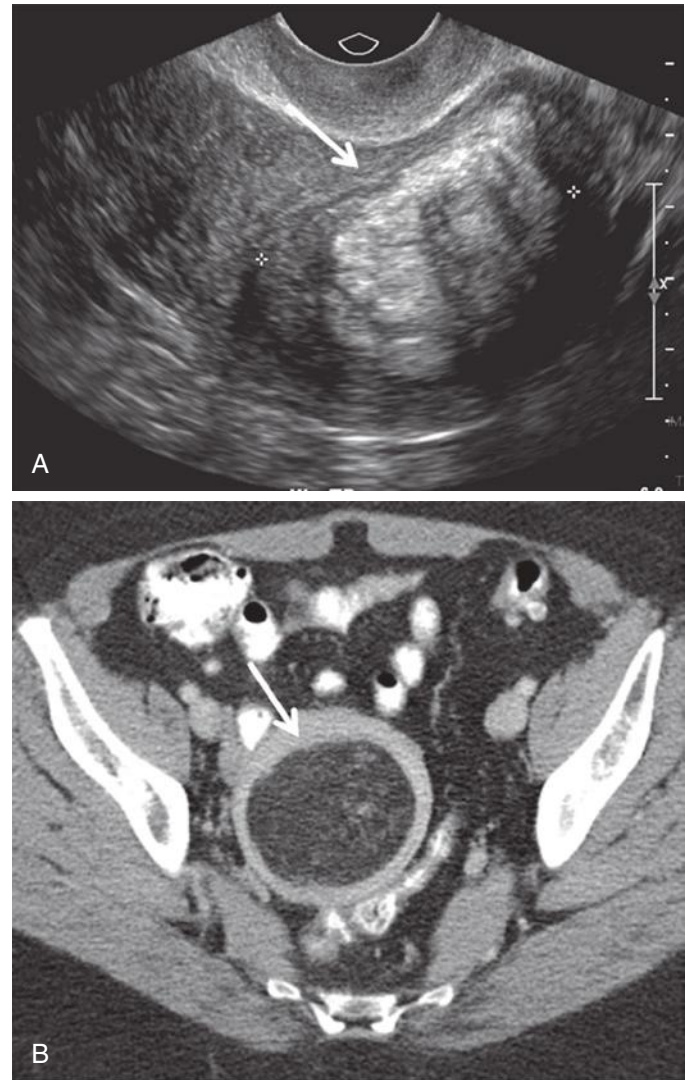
Lipoleiomyoma. A, Hyperechoic heterogeneous mass (arrow and calipers) in the uterus with a slightly lobular contour. B, Computed tomography confirms the presence of low attenuation fat within the uterine mass (arrow) confirming the diagnosis of intramural lipoleiomyoma.
